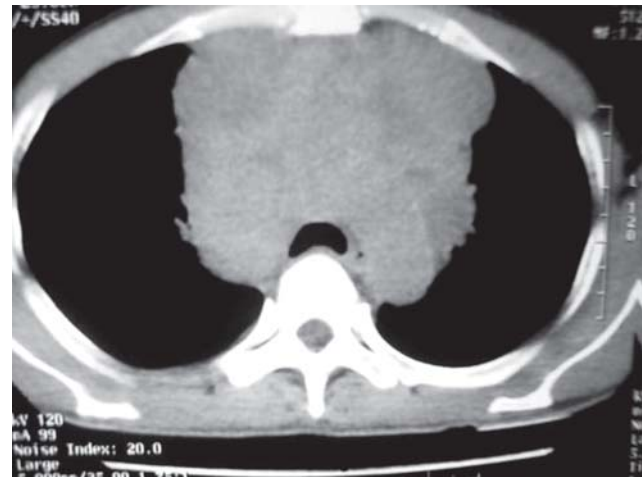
Contrast-enhanced CT scan of thorax showing a large anterior mediastinal mass lesion.
